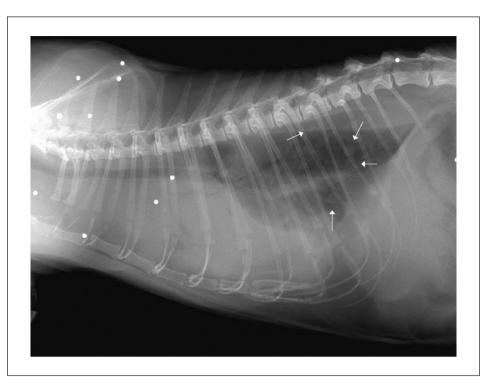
Lateral thoracic radiograph. A large volume of pleural fluid obscures the heart silhouette and other soft tissue structures. Only part of the dorsocaudal lung remains visible. Here, severe pulmonary nodules can be identified (arrows). The bullets can be localised in the thoracic wall and the neck
